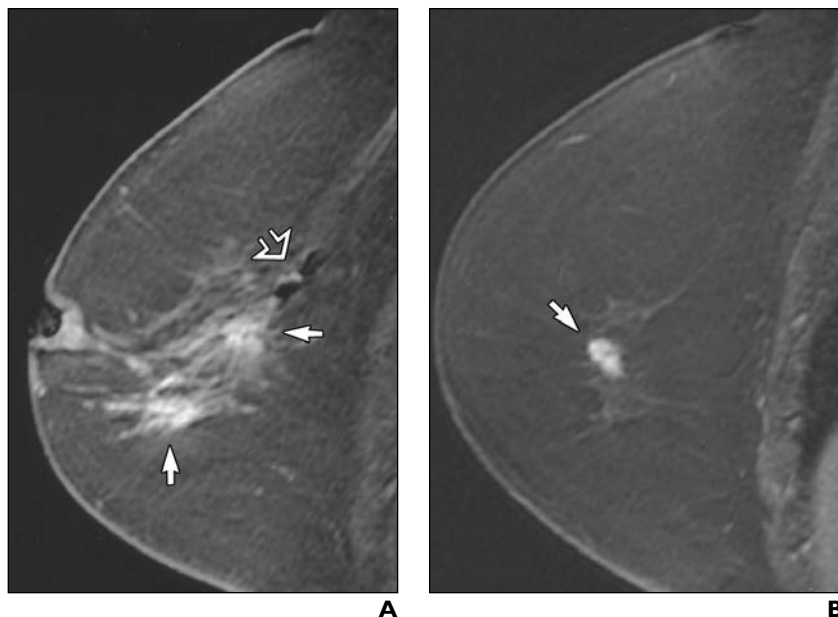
63-year-old woman 2 years after excision of ductal carcinoma in situ (DCIS) in left upper outer quadrant. Mammogram (not shown) revealed moderately dense breasts with two spiculated masses in left breast at 3:00 and 5:00 axes. Sonography-guided core biopsy yielded infiltrating mammary carcinoma with ductal and lobular features from both sites.
